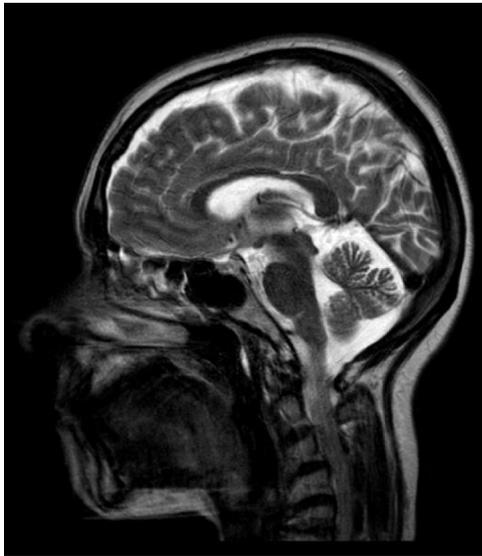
Brain T2-weighted MRI scan, sagittal plane, showing mild cerebellar atrophy for the patient's age.
